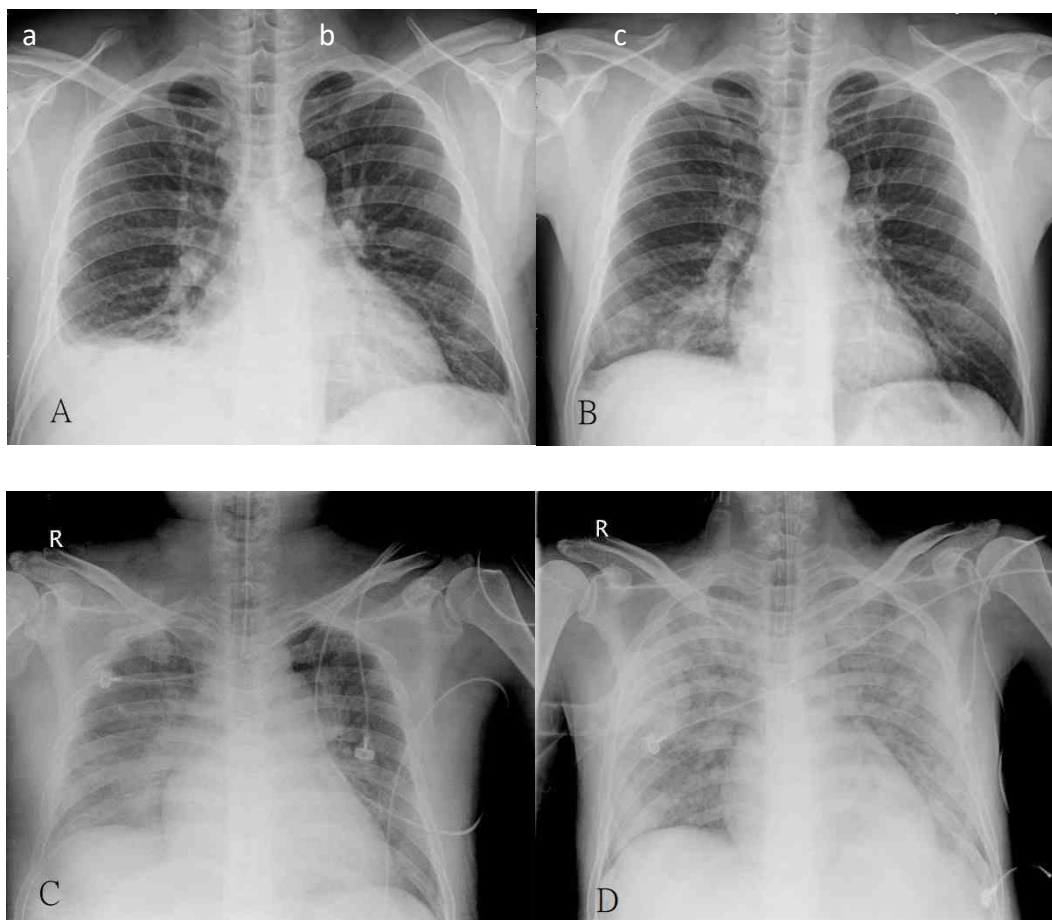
A. The chest X-ray from three years ago revealed blunting of the right costophrenic angle and increased infiltration in the right lower lung field. Right pneumonia with empyema was suspected. B. Two years ago, the chest X-ray revealed increased infiltration in the right lower lung field. Pneumonia was suspected at that time. C. Consolidation was noted in the bilateral hilar area, and acute lung edema was suspected. An endotracheal tube was also inserted for acute respiratory failure. D. Diffuse infiltration was noted in the bilateral lung fields, and peripheral lung involvement was predominant.
